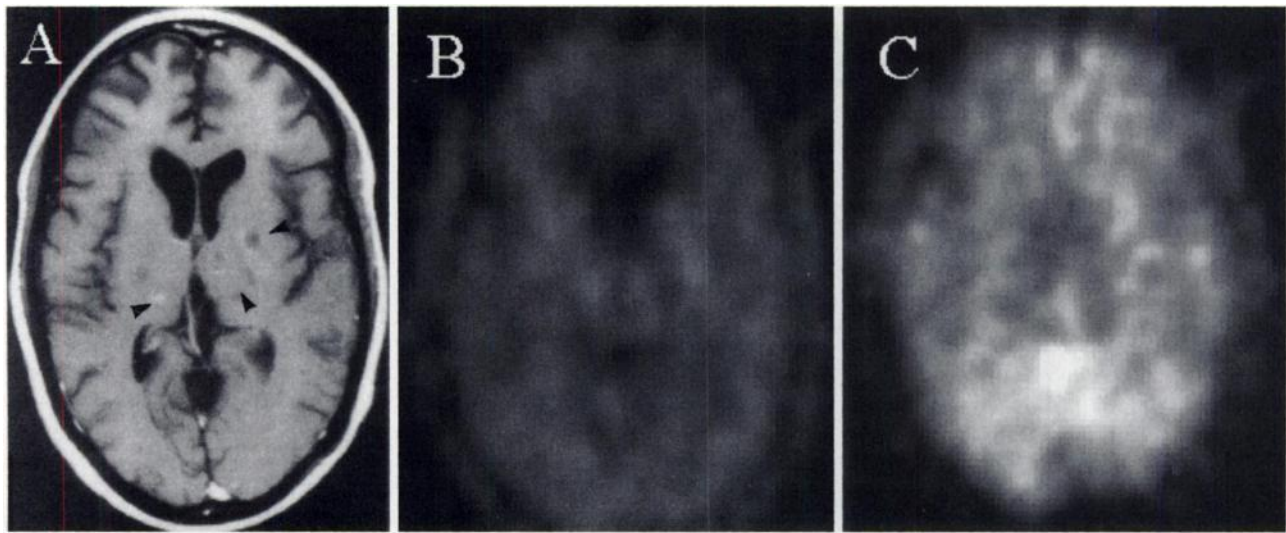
MR appearances in a patient with cerebral toxoplasmosis (indicated by arrowheads) (A), demonstrating the low-grade uptake of FDG (B) and MET (C) within the lesions, indistinguishable from adjacent normal brain tissue.
